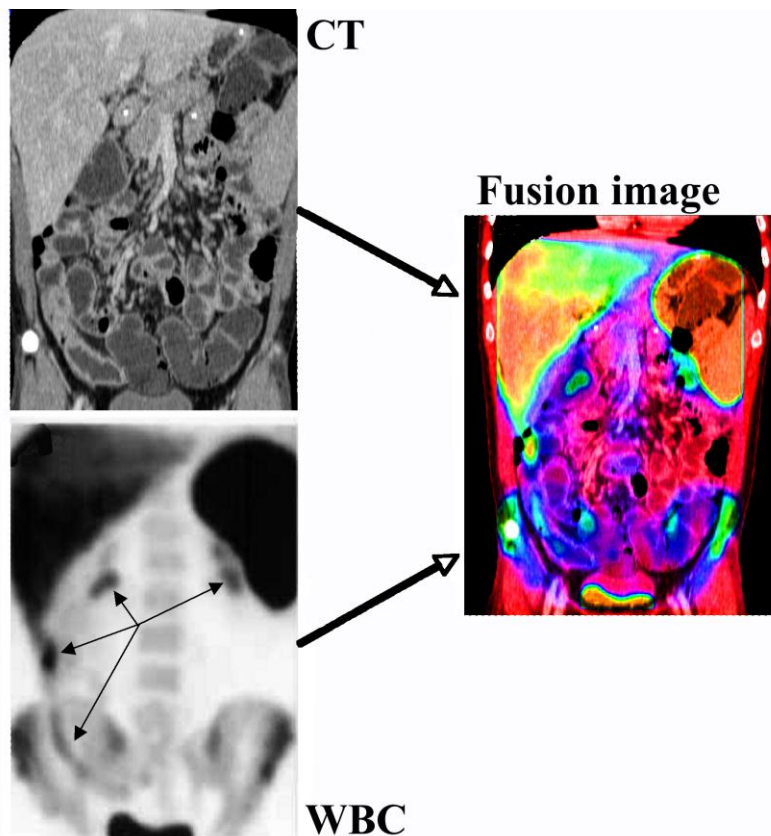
CT enteroclasia (top left) shows a parietal thickening (10.8 mm) involving most ileum and particularly the distal part, with increased vascularity and a mesenteric hypertrophy. Tc-99m-WBC scan (bottom left) shows only focal leukocyte infiltration in four different ileal segments (small arrows). The post-processing fusion imaging of the two studies, allows us to better co-localize the lesions and to obtain an important patho-physiological information (parts of affected ileum are fibro-stenotic without leukocyte infiltration; other segments show signs of acute inflammation). Similar information can be obtained using hybrid imaging with SPECT/CT.
